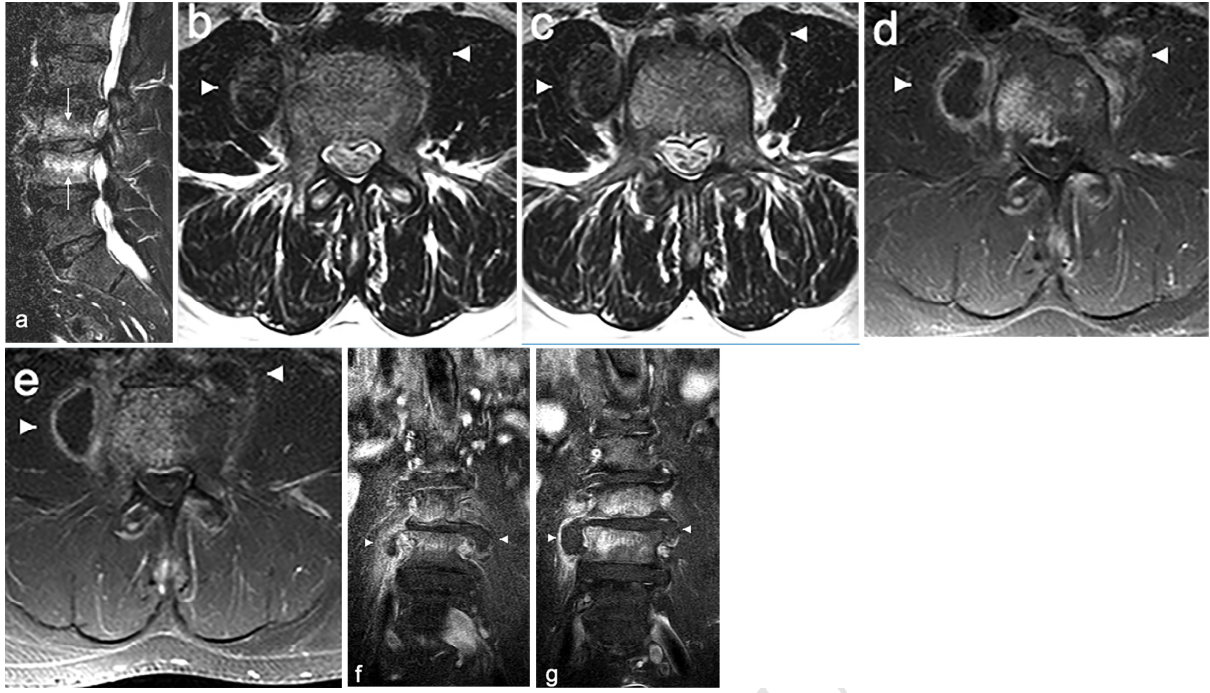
Intial MRI (*a*, sagittal plane T2-TIRM; *b-c*, axial plane TSE-T2; *d-e*, axial plane Gadolinium enhanced fat suppressed T1; *f-g*, coronal plane Gadolinium enhanced fat suppressed T1) showing a T2-TIRM hyperintensity in the L3-L4 intervertebral disc and adjacent endplate consistent with oedema (arrow). Lesion in the psoas muscle (arrowheads *b-g*) isointense or slightly hyperintense T2 to muscle (*b-c*), hypo-intense on fat suppressed T1 with peripheral ring enhancement (*d-g*) in continuity with the L3-L4 endplate enhancement (*f-g*).
